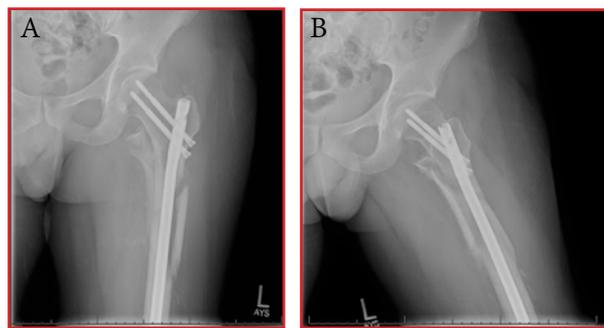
Postoperative radiographs of the left femur at 8-week follow-up. A) Anteroposterior view. B) Lateral view.
